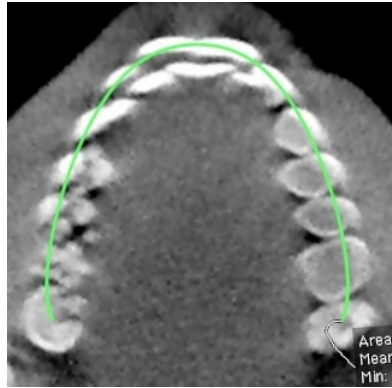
Cut Line: CBCT Simple Pano OsiriX
